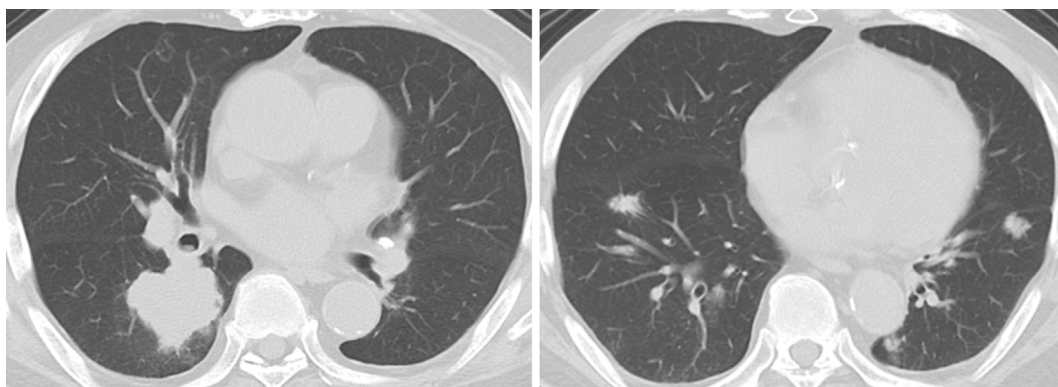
Chest CT shows a 50-mm mass in the right lower lobe and multiple nodules in both lungs.
